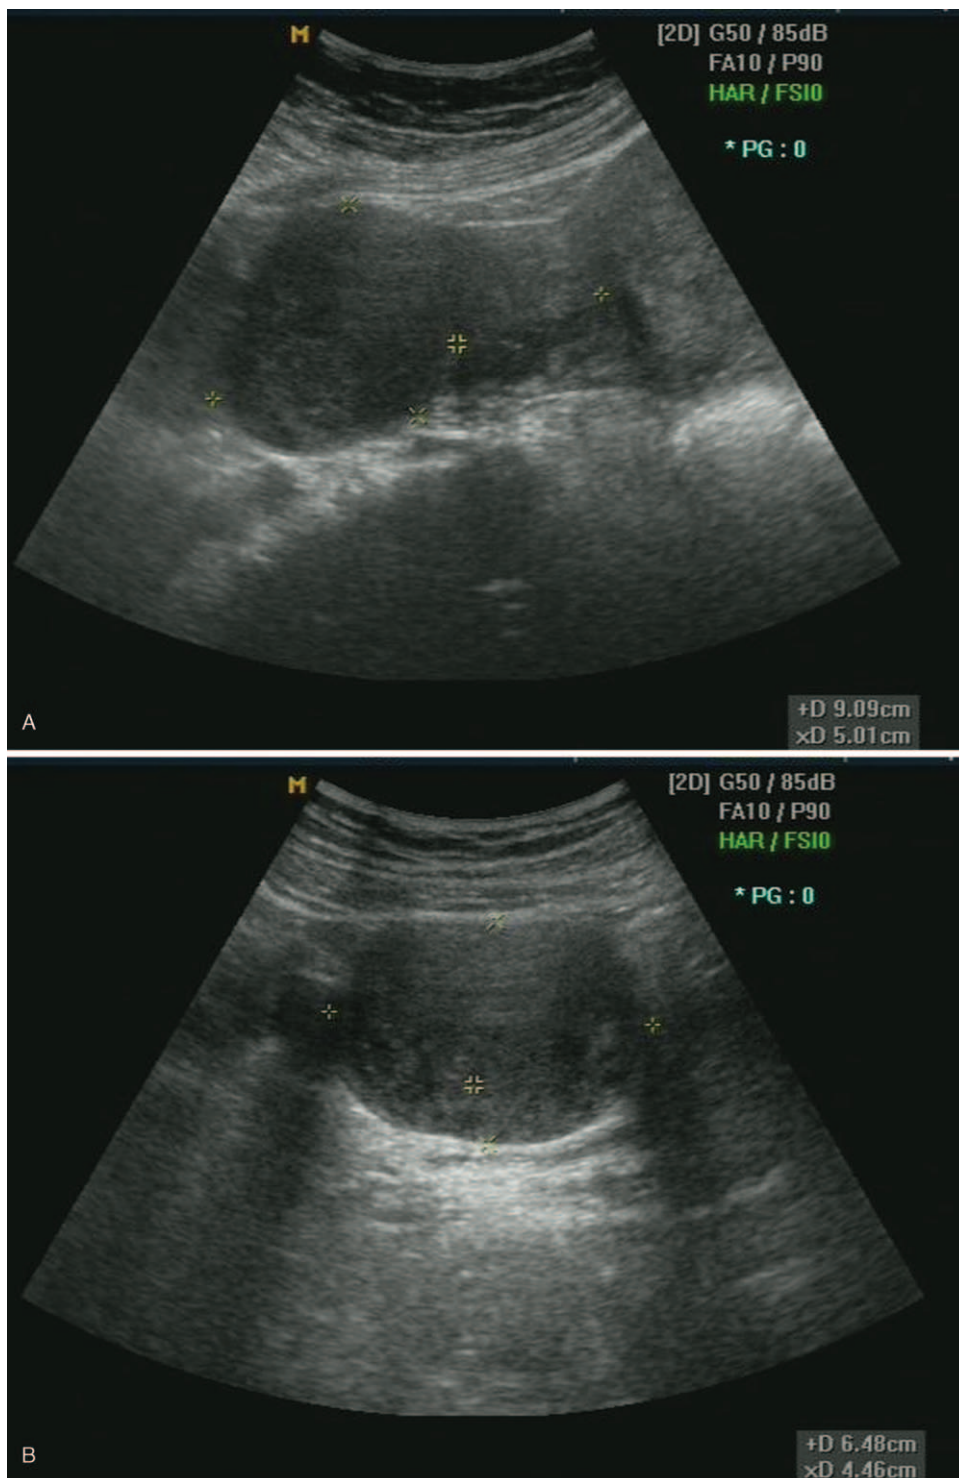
The ultrasound scan during second pregnancy. (A) a decreased myoma (9.1 × 5.0 cm) at the uterine fundus at 6 weeks of pregnancy. (B) myoma size decreased to 6.5 × 4.5 cm (C) myoma completely regressed 4 years later after second delivery.
